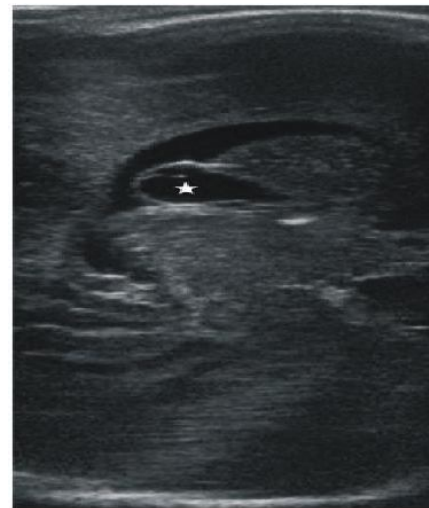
Neurosonogram Coronal Image Shows Dilated Lateral Ventricles (Frontal Horn) with Subependymal Cyst (*) Formation - 4 Week Scan
